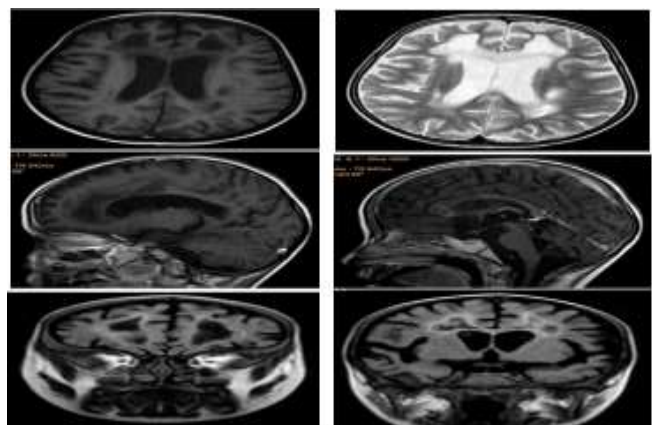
MRI features of the Patient
